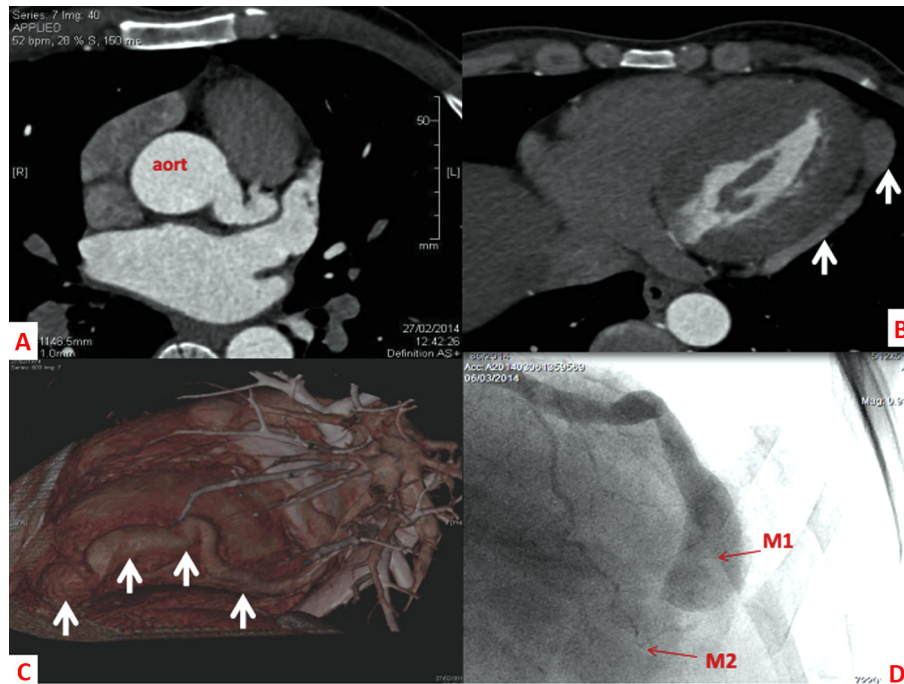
(A) Cardiac computed tomography (CT)-scan axial slice showing left main coronary ectasia; (B) cardiac CT-scan multiplanar reconstruction (MPR) showing marginal coronary artery aneurysm (arrows); (C) cardiac CT-scan volume rendering technique (VRT) showing the tortuous course of the marginal coronary artery (arrows); and (D) cardiac catheterization, left anterior oblique view showing coronary aneurysm (red arrows). aort = aorta; M1 = septal cystic mass; M2 = epicardial cystic mass.
